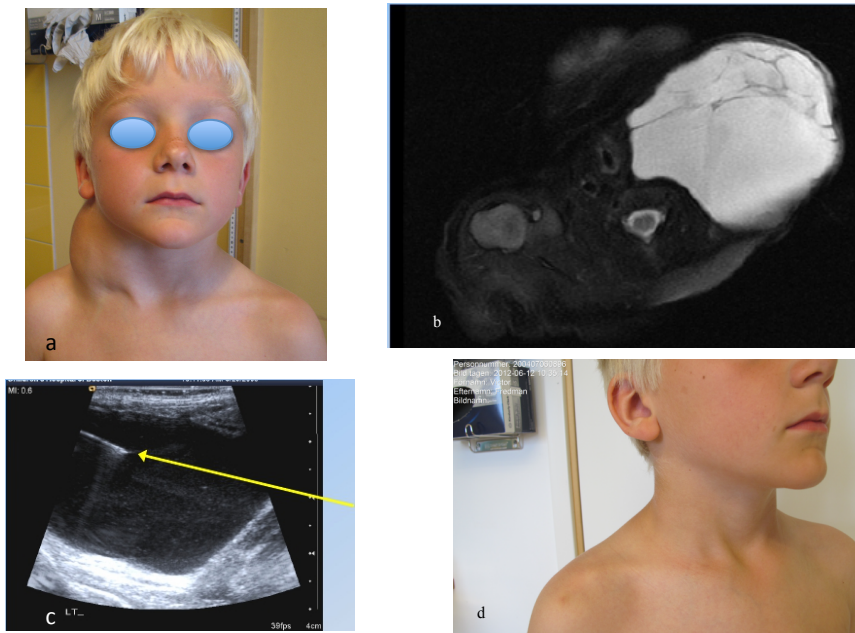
Macrocystic LM a clinical features, b MRI T2 weighted image of large fluid filled cysts, c Ultrasound guided puncture of cysts and injection of OK-432, d Clinical outcome after one sclerotherapy session.
